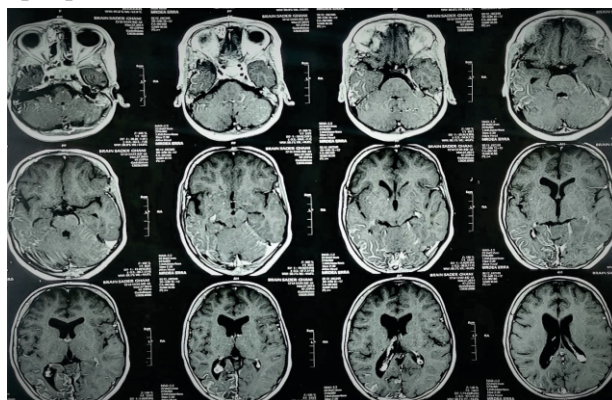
MRI with contrast demonstrating leptomeningeal enhancement in right temporal and occipital regions.
